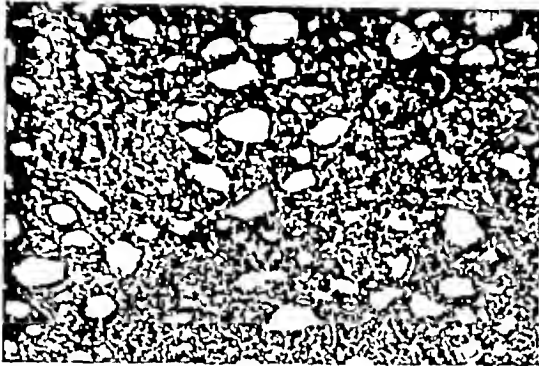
Showing the thyroid of an opossum (65) on meat diet that received two series of X-ray treatments. Hyperplasia has occurred but not to the extent as the controls on meat diet without X-ray. Magnification 60 times
